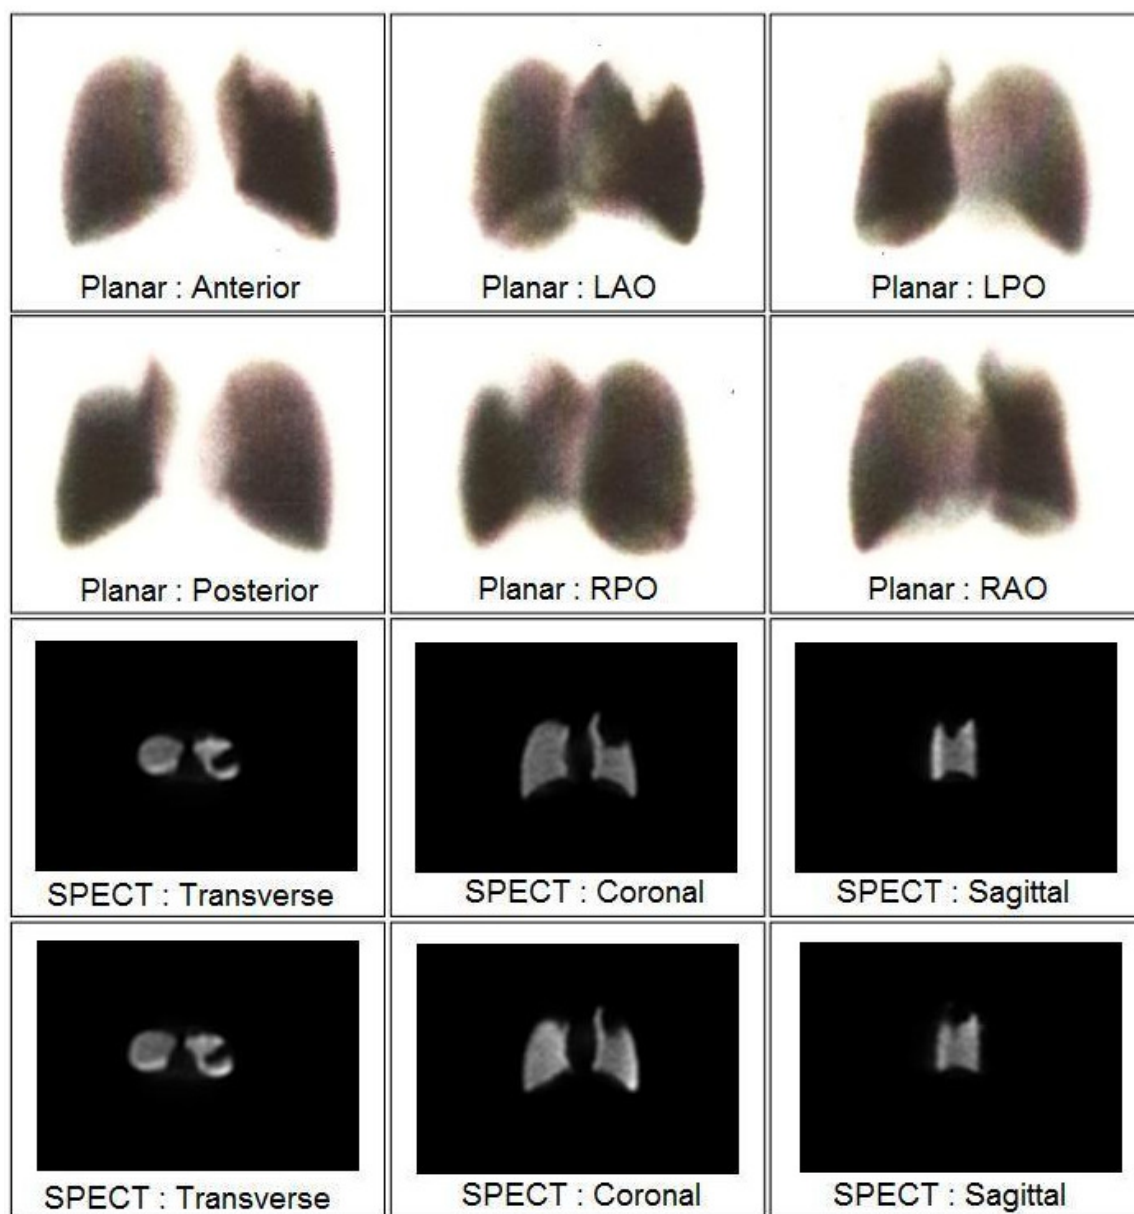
Planar and SPECT images of a perfusion defect within the apical and posterior segment of the left upper lobe.
